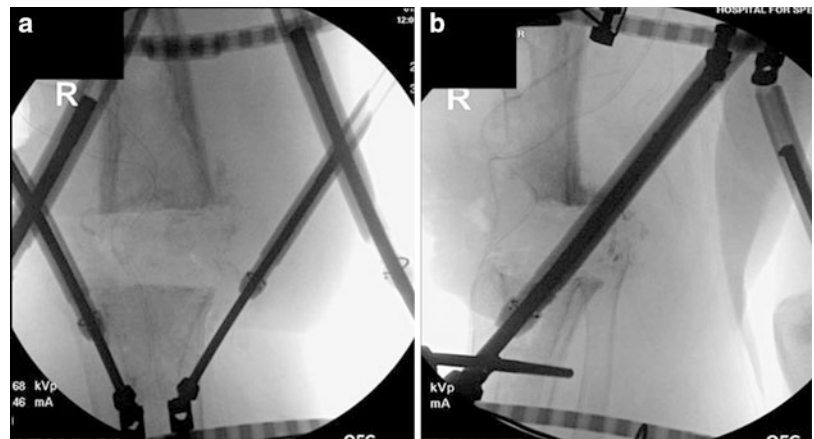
(a, b) Intraoperative (a) AP and (b) lateral radiographs of the right knee after application of the TSF demonstrating intraoperative acute partial reduction of the gap across the knee joint to a 6-cm gap. This was the maximum amount of acute shortening tolerated by the skin still enabling primary closure
